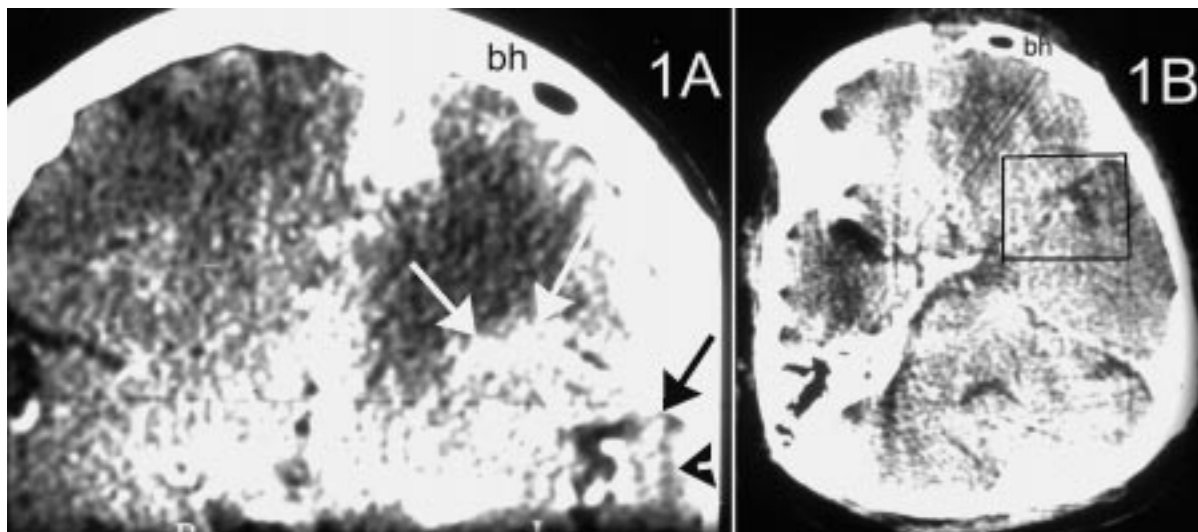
(A) CT of the brain with intravenous contrast, revealing an enhancing left subfrontopolar lesion adjacent to the crista gali (black arrow and arrowhead) and surrounded by edema (white arrows). Burr hole is indicated by bh. (B) Repeat CT one day following the operation. A complete resection of the lesion is evident. The indicated rectangle is the area in which the resection was performed.
